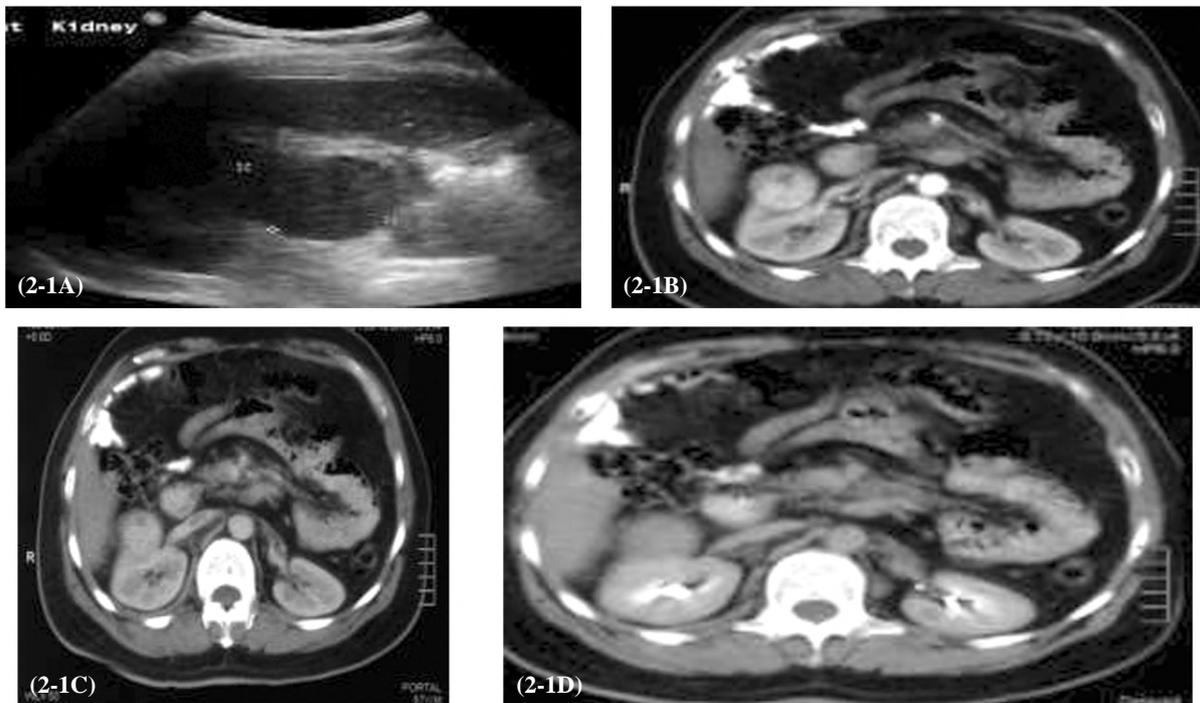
A: Abdominal US shows echogenic soft tissue mass lesion involving middle zone of right kidney. B, C, D: Axial contrast enhanced CT images (arterial, nephrographic and excretory phase respectively) shows right renal middle zone anterior cortical enhanced soft tissue mass lesion measures 4 X 4.5cm, planned for RFA (Radio Frequency Ablation) because his co morbidity (hepatic cirrhosis).
